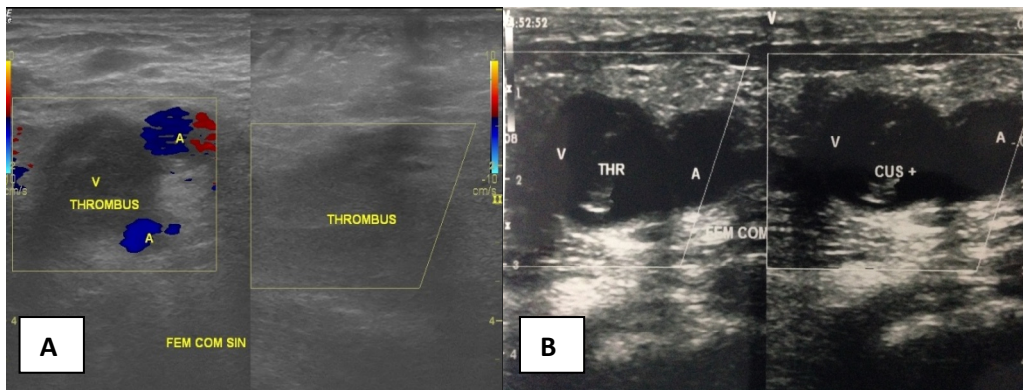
A.) Femoral duplex sonography before CDT showed thrombus in left common femoral artery. B.) Femoral duplex sonography after CDT showed thrombus dissolution.
